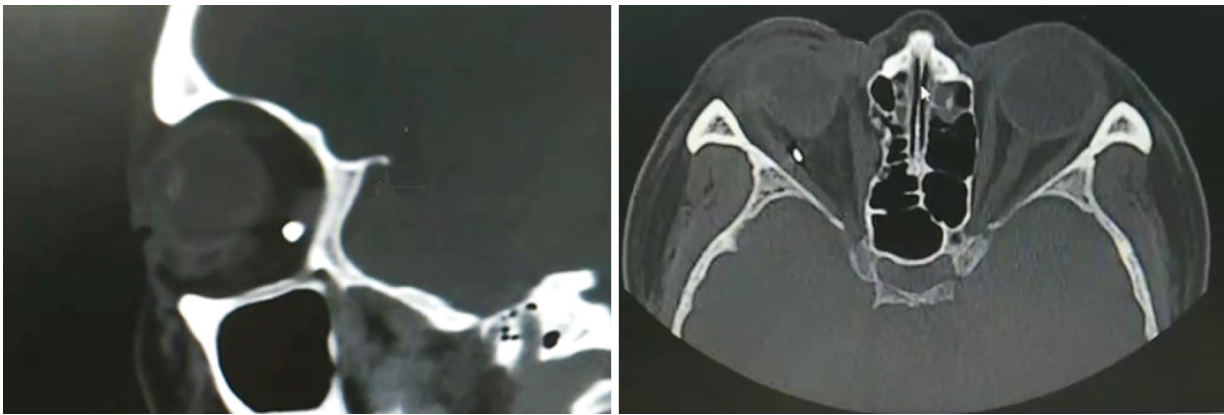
Orbital computed tomography showed a foreign body behind the right eyeball located discontinuously with the posterior wall of the eyeball.
